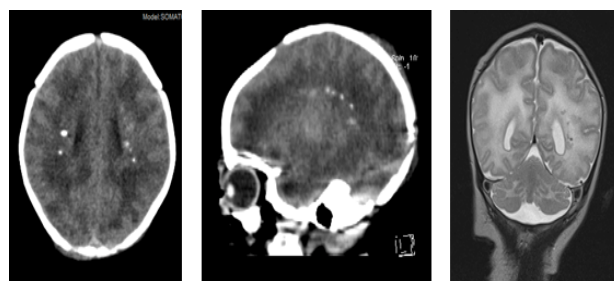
Computed tomography and magnetic resonance imaging of the brain showing attenuation of cerebral white matter, subcortical atrophy and basal ganglia and periventricular calcifications.
